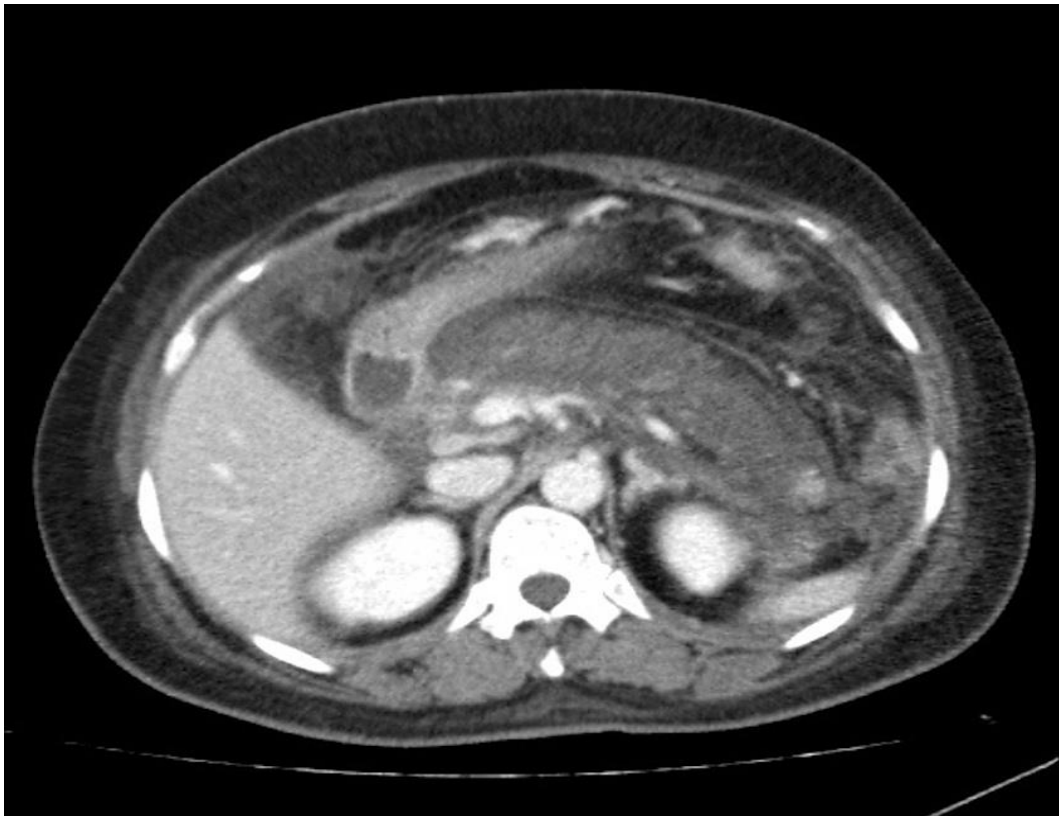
Abdominal CT scan shows a swollen pancreas with some peripancreatic fluid accumulation and peripancreatic fat infiltration.
